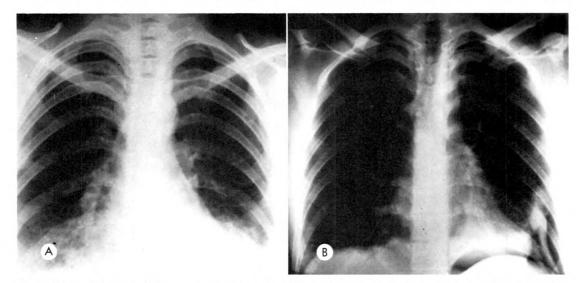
Case I. (A) Frontal chest roentgenogram shows bilateral basilar bronchopneumonia. (B) Frontal chest roentgenogram immediately after thoracentesis shows the crescentic gas lucency of subpulmonary pneumothorax. Intrapleural gas can be seen extending laterally about the diseased lower lobe.
